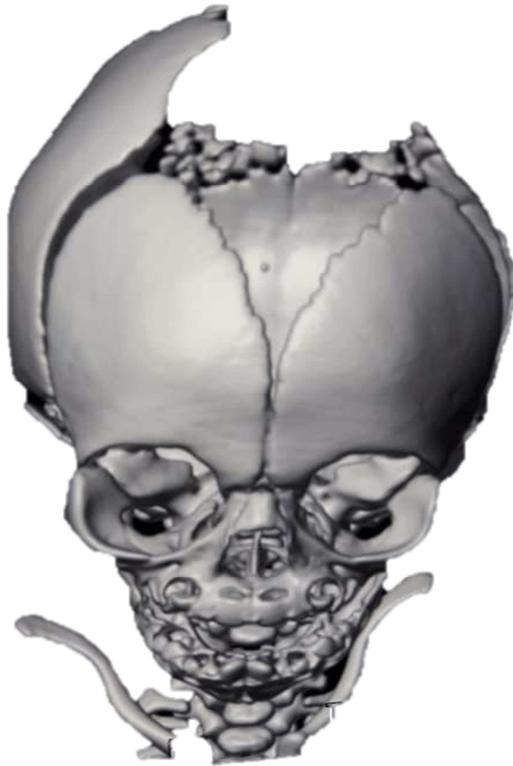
3D CT reconstruction of Skull defect.
